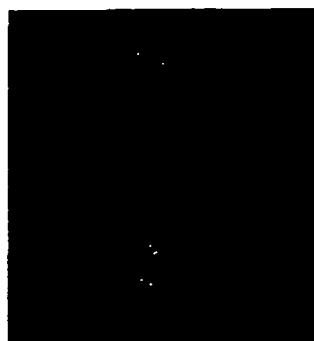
Radiograph showing the two RESUME motor cortex stimulation electrodes placed on the hand and foot areas.
